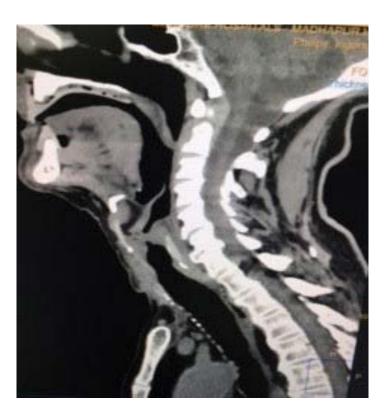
CT NECK sagittal view showing supraglottic narrowing
